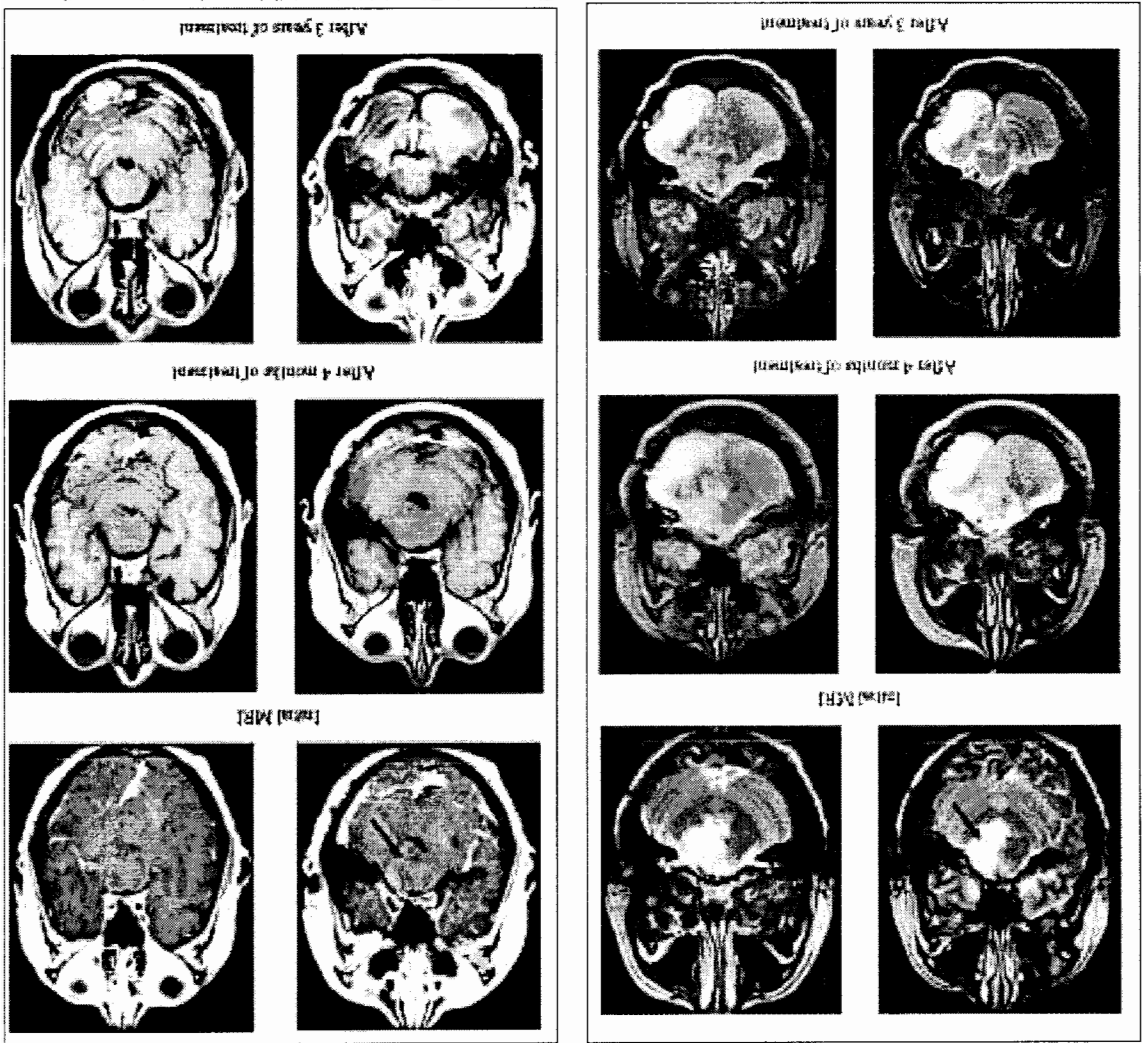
A T1-weighted gadolinium-enhanced magnetic resonance image of the head corresponding to T2-weighted images shown in Figure 2.
